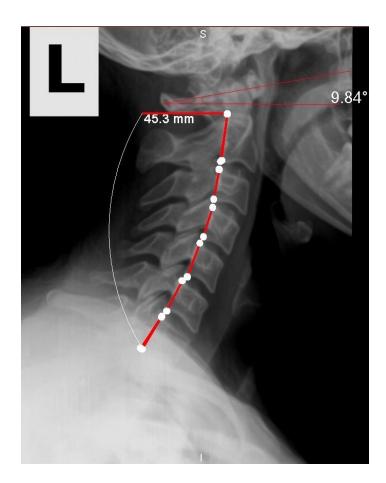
Preliminary X-Rays: Neutral Lateral Cervical
